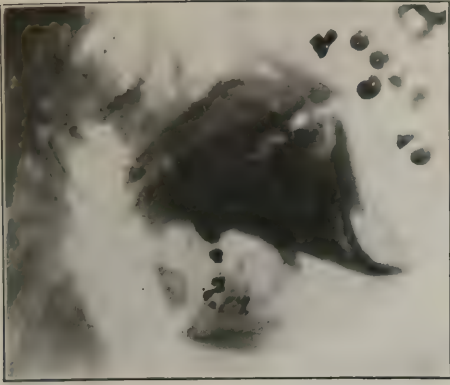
Case 1: Pedicled graft from mandible. Radiograph showing loss of substance.
